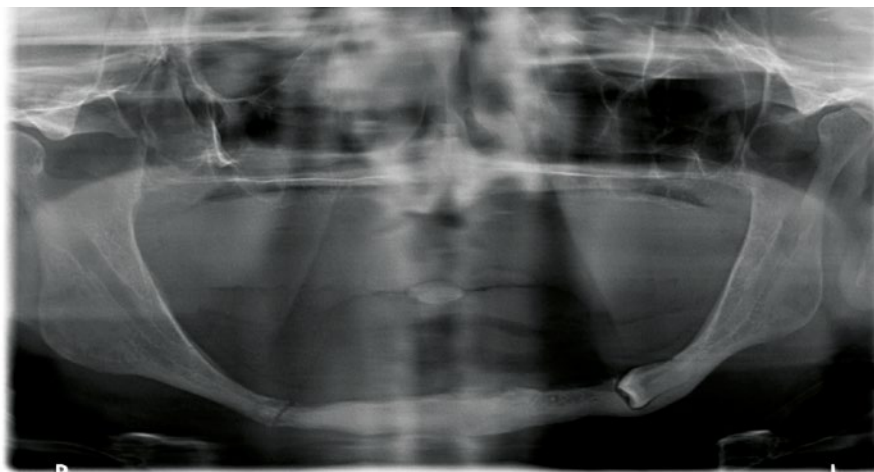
A full panoramic radiograph identifying the horizontally ectopic lower left premolar and a complete, undisplaced mid-body mandibular fracture on the right-hand side
